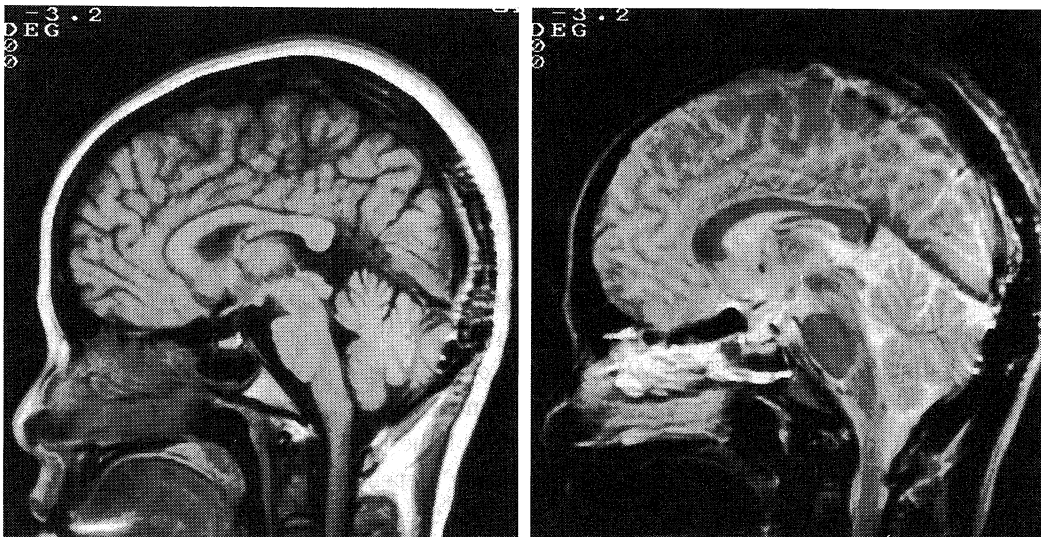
Sagittal, postoperative T1-weighted image (left) and T2-weighted image (right) showing subtotal resection of the cyst and relief of compression to the superior colliculus.
